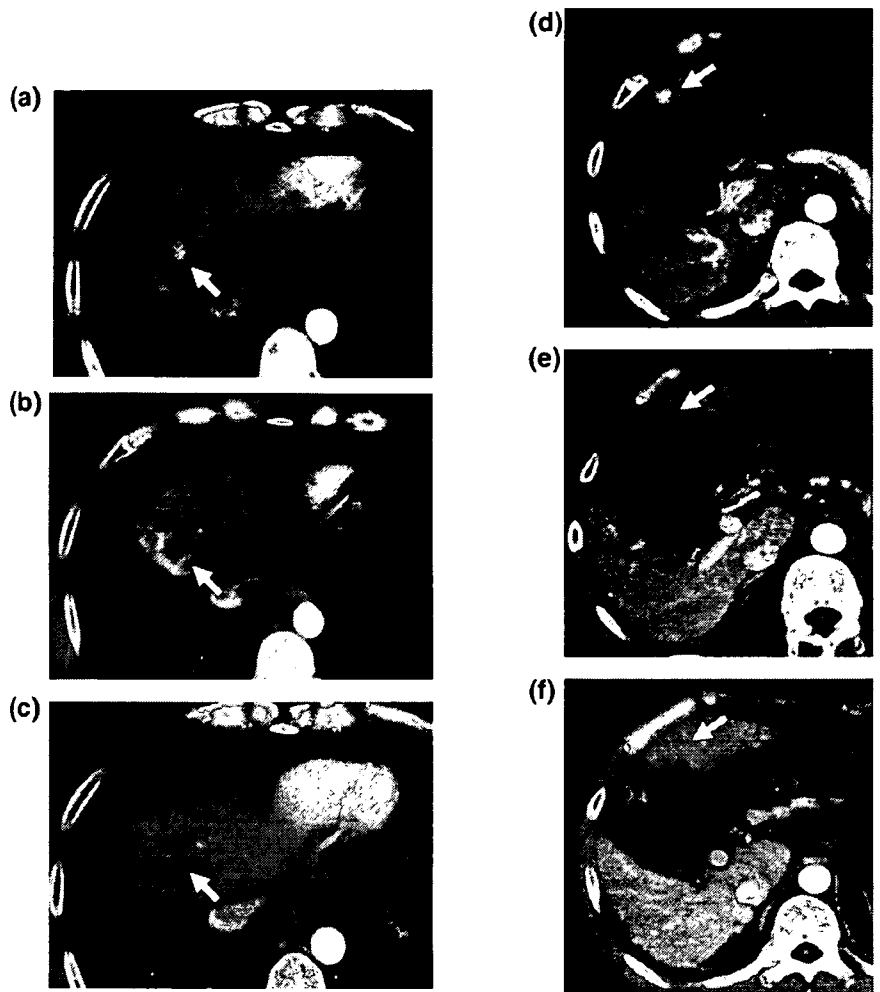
A 48-year-old man with multiple tumors of hepatocellular carcinoma (HCC) after hepatectomy, percutaneous ethanol injection, and transcatheter arterial embolization. (a) Hypervascular HCC lesion, 1 cm in diameter, was revealed at the early phase of dynamic computed tomography (CT) before administration of sorafenib at the anterior superior segment of the liver (arrow). (b) The vascularity of this tumor disappeared 1 month after the administration of sorafenib. (c) The tumor was reduced 3 months after the administration of sorafenib. (d) Another hypervascular HCC lesion, 1 cm in diameter, was revealed at the early phase of dynamic CT before administration of sorafenib in the left lobe of the liver (arrow). (e) The vascularity of this tumor disappeared 8 months after the administration of sorafenib. (f) The tumor almost completely disappeared 10 months after the administration of sorafenib.
